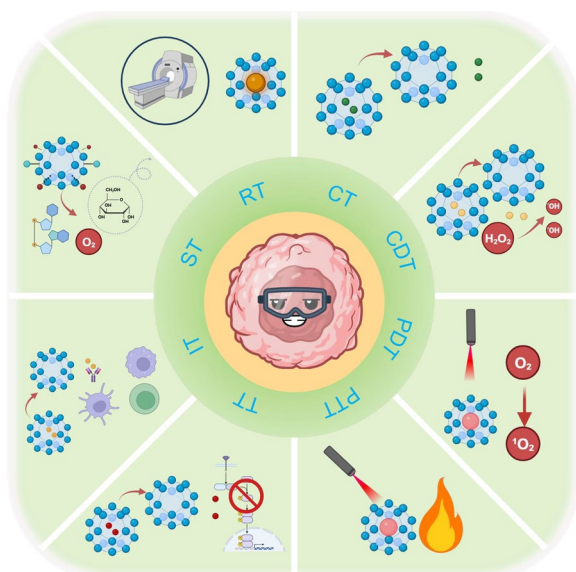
Main methods for cancer therapy and the roles of MOFs in them. MOFs can load chemotherapy drugs for CT, while their metal ions can produce Fenton or Fenton-like reactions for CDT. MOFs can load photosensitizers for PDT, photothermal agents for PTT. MOFs can also be an carrier of small molecule targeted drugs and immunotherapy drugs for TT and IT. Additionally, MOFs can also load and protect GOx for ST and carry radiosensitizers to improve RT. RT radiotherapy, CT chemotherapy, CDT chemodynamic therapy, PDT photodynamic therapy, PTT photothermal therapy, TT targeted therapy, IT immunotherapy, ST stavation therapy
